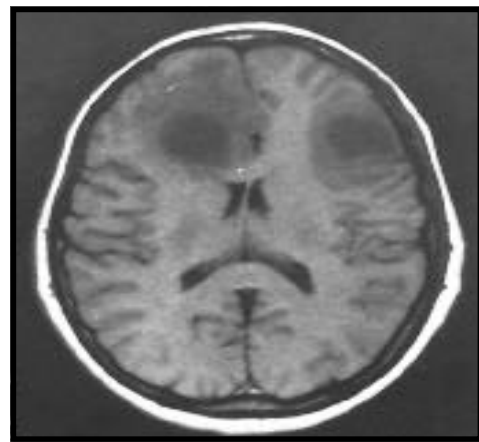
Axial brain MRI, showing the 2 lesions of the same patient.
